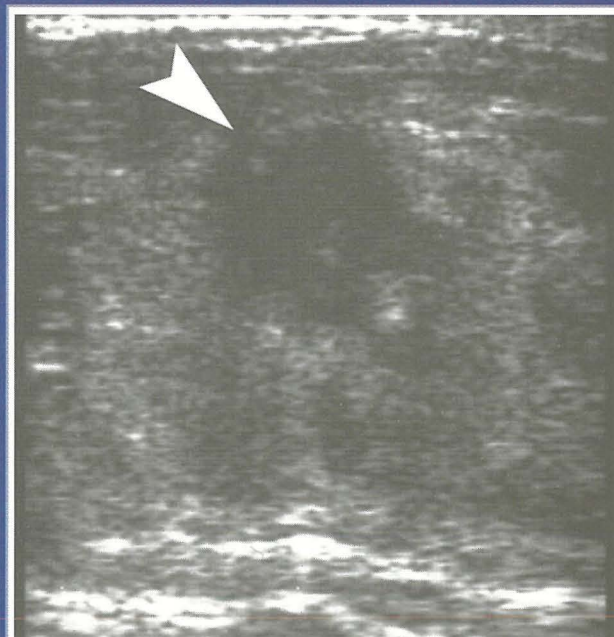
Secretory breast cancer: Ultrasound scan reveals a hypoechoic mass (arrowhead) with irregular borders and an anti-parallel growth pattern.
